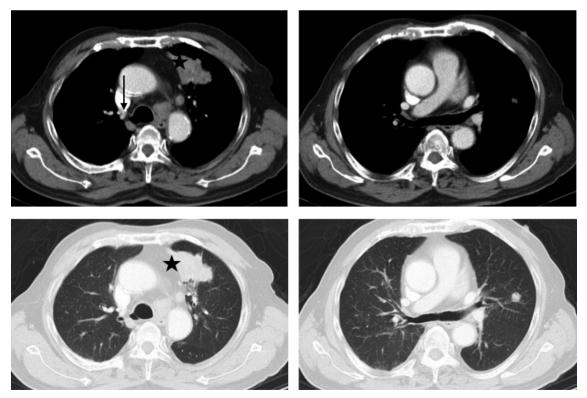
Chest CT revealed a mass lesion at the left upper lobe (star) and a pulmonary nodule at the left lower lobe. A tracheal bronchus originating from the right-side tracheal wall (arrow).
